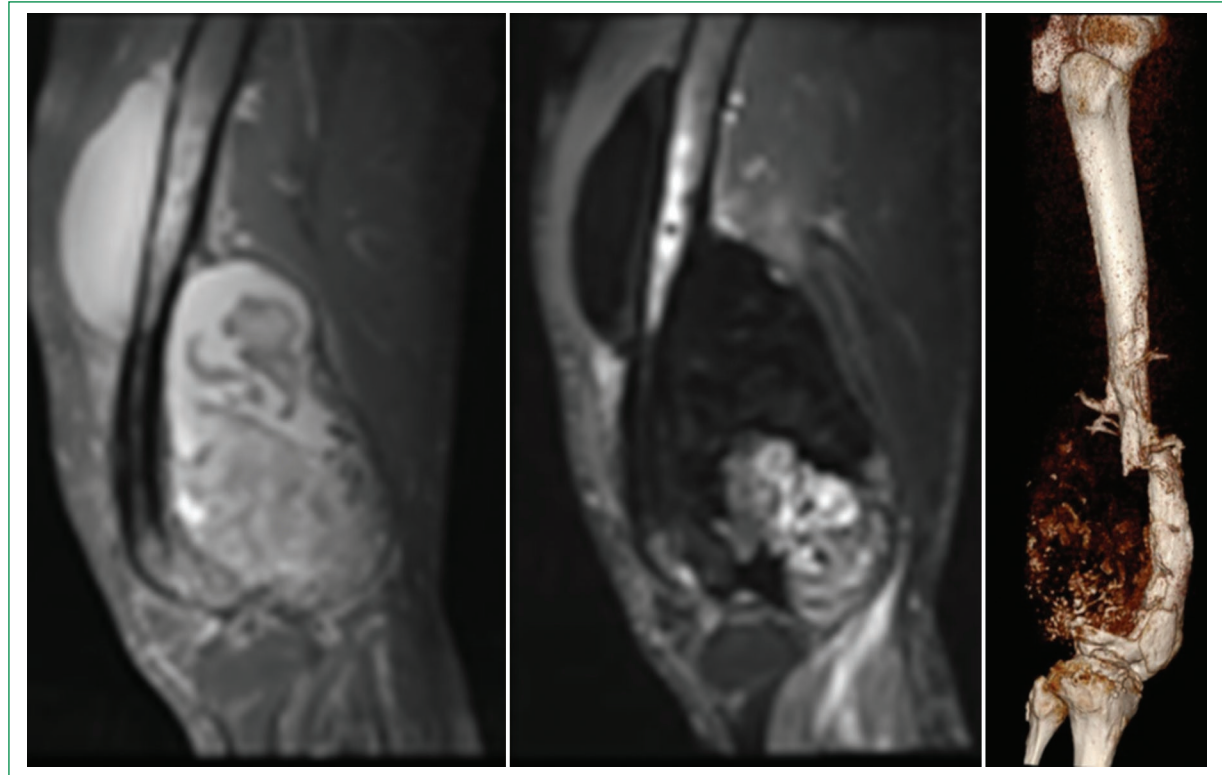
CT scan and 3D reconstruction showing a displaced and overriding fracture associated with a known pseudotumor.
